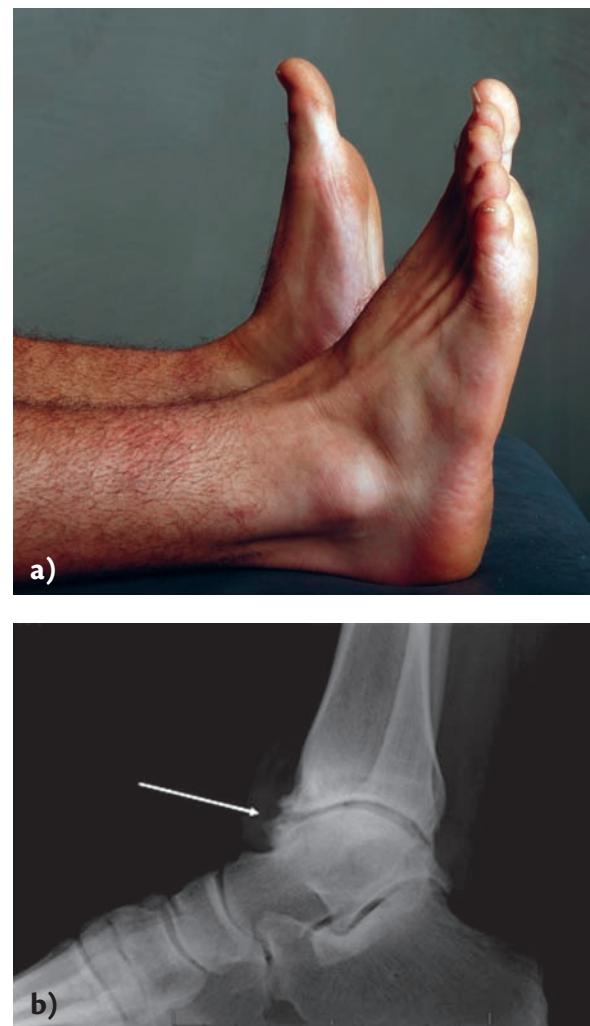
Impingement in the ankle. a) Impingement of the ankle is characterized by decreased mobility in the ankle especially during dorsiflexion (the foot is bent upwards); b) X-ray of the ankle showing bony osteophytes on the anterior aspect of both the tibia and the talus (arrow).
